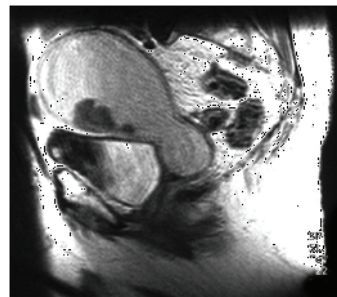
MRI showing Uterine Papillary Serous Carcinoma Patient was taken up for Staging Laparotomy
